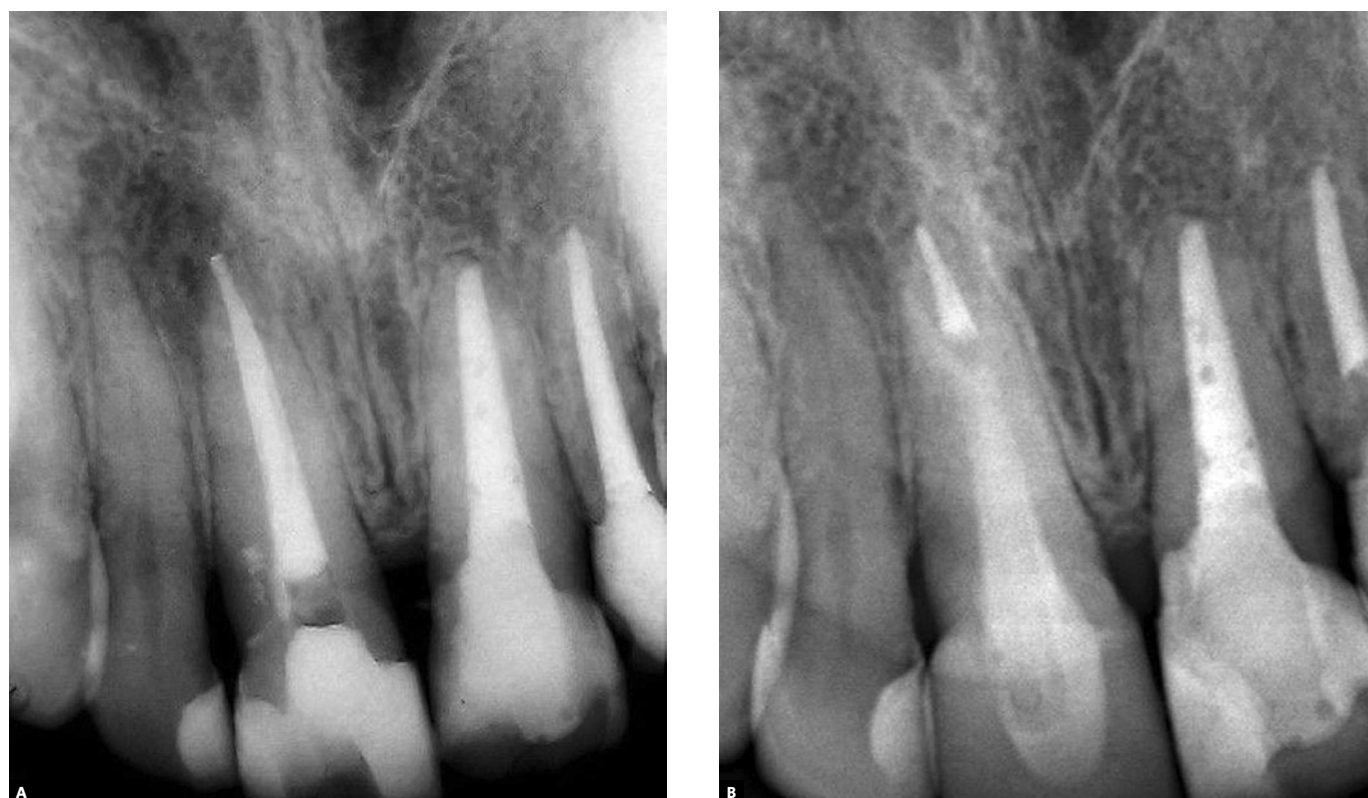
A) Final radiograph taken immediately after filling was completed; B) Post-operative control radiograph take 2 years and 6 months after treatment was completed.
